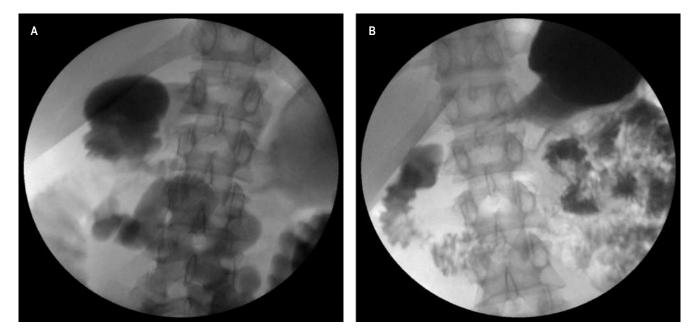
Gastroduodenal series. Radiographic imaging show proximal dilatation of the duodenum (\mathbf{A}) , with a significant compression in the midline of the third portion of the duodenum (\mathbf{B}) .
